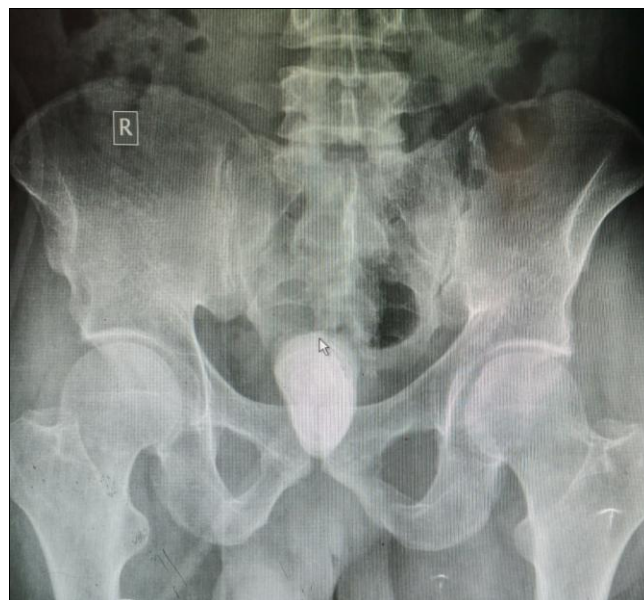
Plain radiograph of the pelvic bone demonstrating a near oval/pyramidal shaped opacity of calcific density having a lamellated appearance measuring about 68mm x 40mm in craniocaudal and mediolateral dimension within the pelvic cavity in keeping with the giant vesical calculus. The demonstrated bones show no fracture
